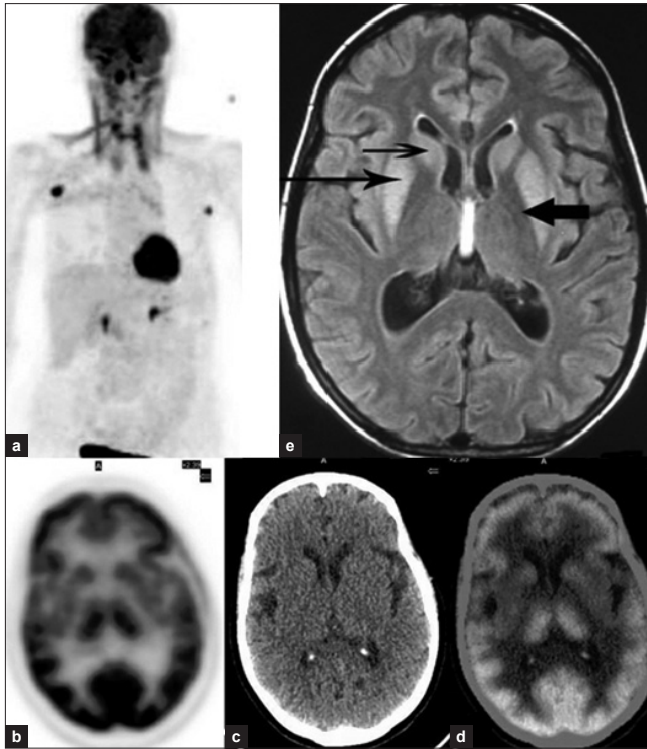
62-year female treated case of Ca breast on follow up with an episode of hyponatremia which was rapidly corrected; (a) Anterior MIP image showing hyper-metabolic axillary nodes heterogeneity in brain FDG distribution is because patient moved her head during acquisition; (b, c, d) Axial plain PET, CT and fused PET/CT images show hypometabolism in both basal ganglia which appear normal on CT; (e) T2 weighted FLAIR MRI image showing bilaterally symmetrical hyper-intensities in Caudate nucleus and Putamen with sparing of Globus Pallidus suggestive of Extrapontine myelinolysis
